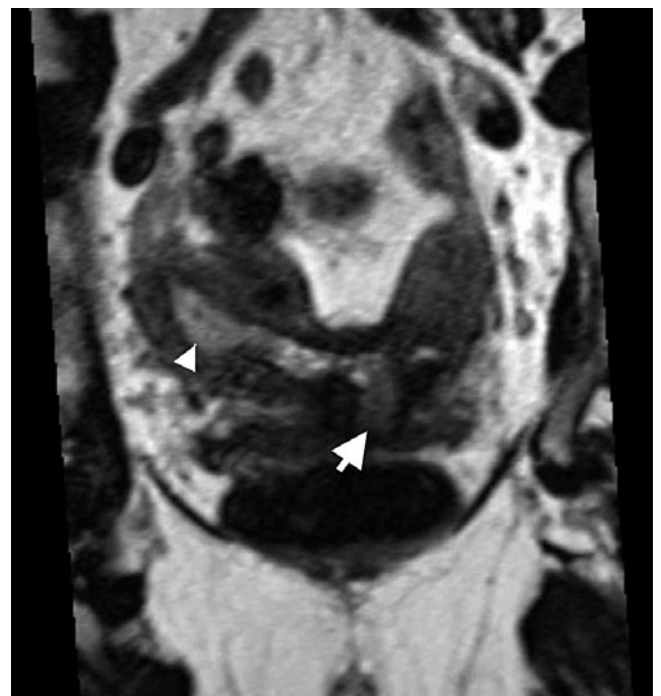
Müllerian duct anomalies (MDA): bicornuate uterus. 3D T2-weighted multiplanar reconstruction (MPR) magnetic resonance image (MRI) in the true coronal plane of the uterus demonstrates divergent uterine horns with a common cervix (*arrow*), consistent with bicornuate unicollis uterus. Note the polyp distending the right endometrial canal (*arrowhead*)
